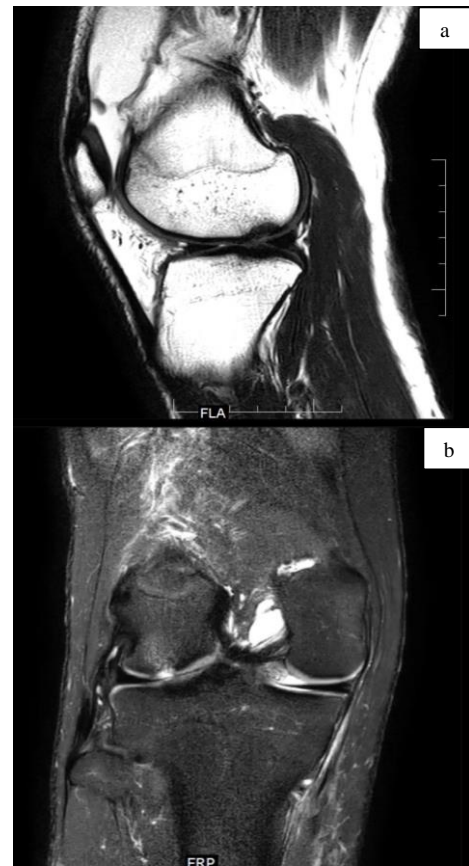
Sagittal and coronal magnetic resonance imaging (MRI) sections of the knee showing osteochondral defect over lateral femoral condyle (a and b)
